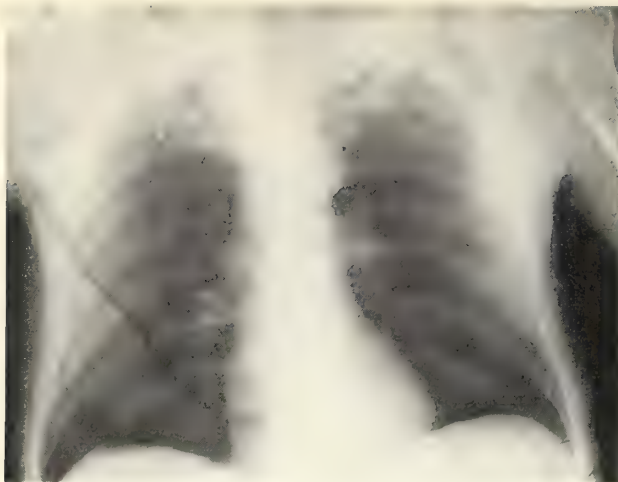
Chest x-ray in October, 1975, showing normal heart with no enlargement.
